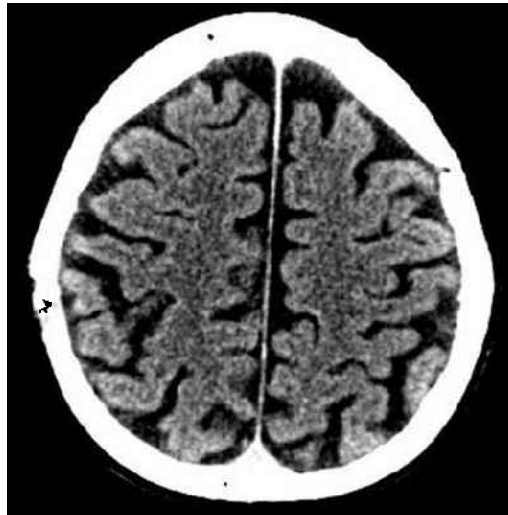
Axial CT image of the brain at one year postoperation shows that the burr hole defect has been covered with native bone.
